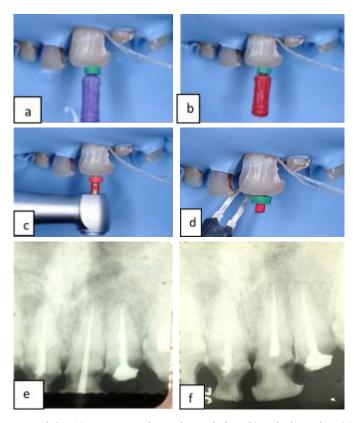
Root canal treatment on tooth 21. (a) Access opening and negotiation, (b) Apical gauging, (c) Canal shaping was done using Protaper gold, (d) Obturation, (e) Gutta-percha point trial, (f) Radiographic view to confirm obturation.
